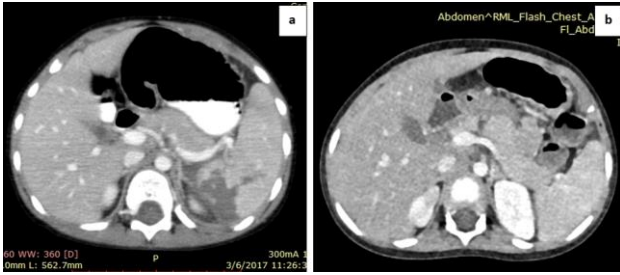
a) Axial CT of splenic laceration. b) Another patient with traumatic transection of pancreas.
